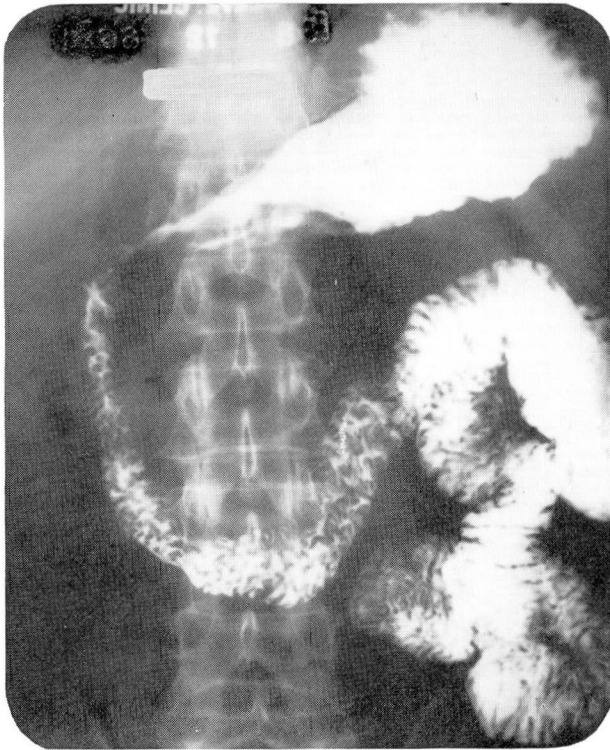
Roentgenogram demonstrating compression with upward displacement of the antrum and widening of the duodenal loop (c-loop).
